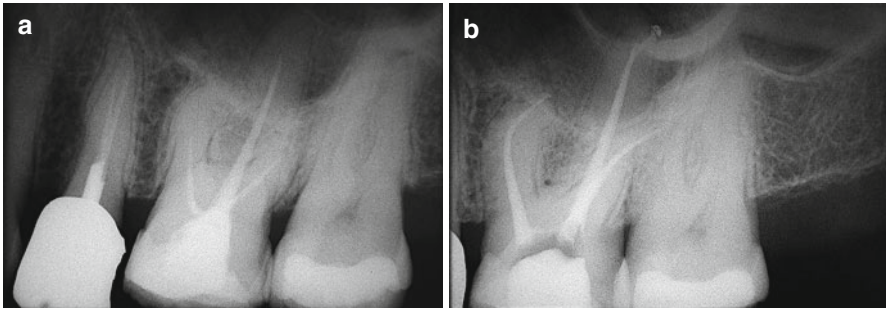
(a) Left maxillary first molar. Endodontic treatment is insufficient and the patient complains of slight pain on mastication. (b) Postoperative radiograph showing retreatment. Note the palatal perforation in correspondence to the apical ledge
